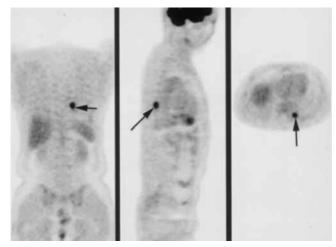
False positive FDG-PET findings demonstrated a hypermetabolism lesion in the left lower middle lung (arrows) with a final diagnosis of pulmonary TB.
